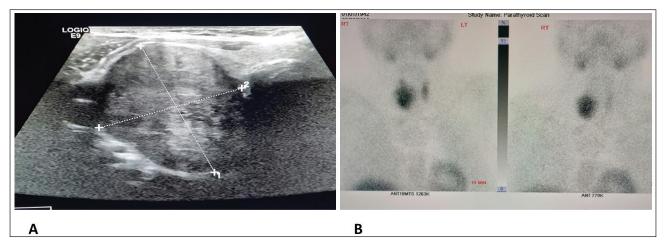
(A) Ultrasonography and (B) Sestamibi scan of the parathyroid of one of the patients, which was the largest parathyroid mass in this case series.
